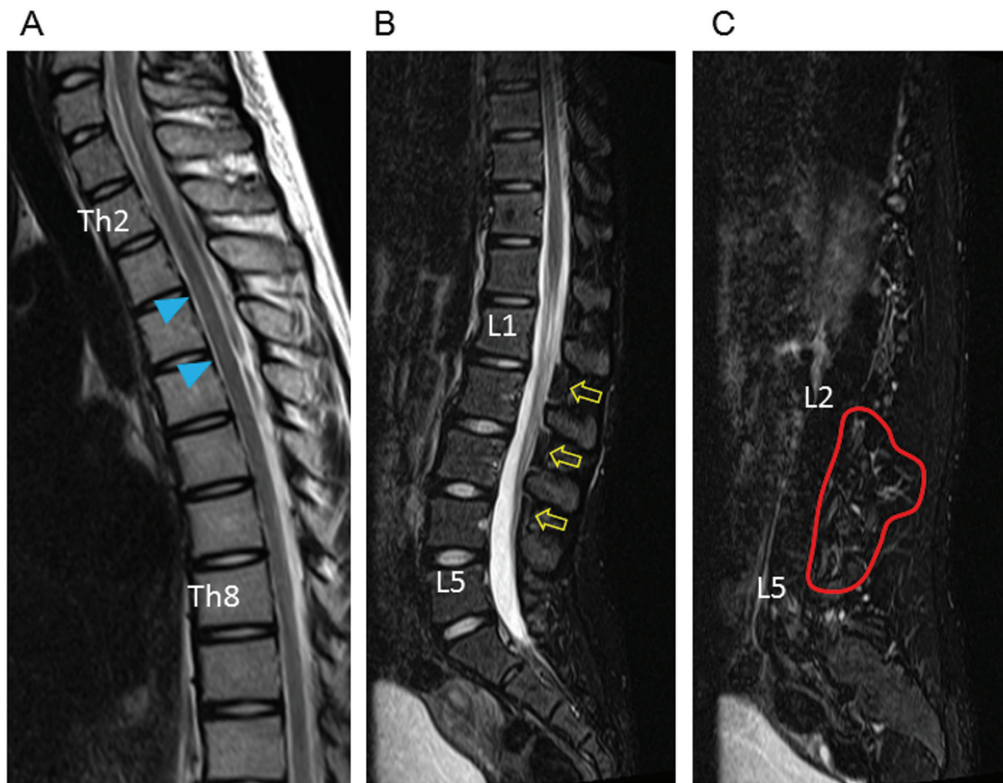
Spinal MRI 10 days after the start of bed rest in case 1. Midsagittal T2WI at the thoracic level (A) shows improvement in the anterior shift of the spinal cord (arrowheads), allowing reappearance of the CSF space in front of the spinal cord. Midsagittal T2-FS image at the lumbar level (B) shows vanished DTS (open arrows). Right paramedian sagittal T2-FS image at the lumbar level (C) shows reduced CSF exudation around the dural sleeves (encircled by red line).
